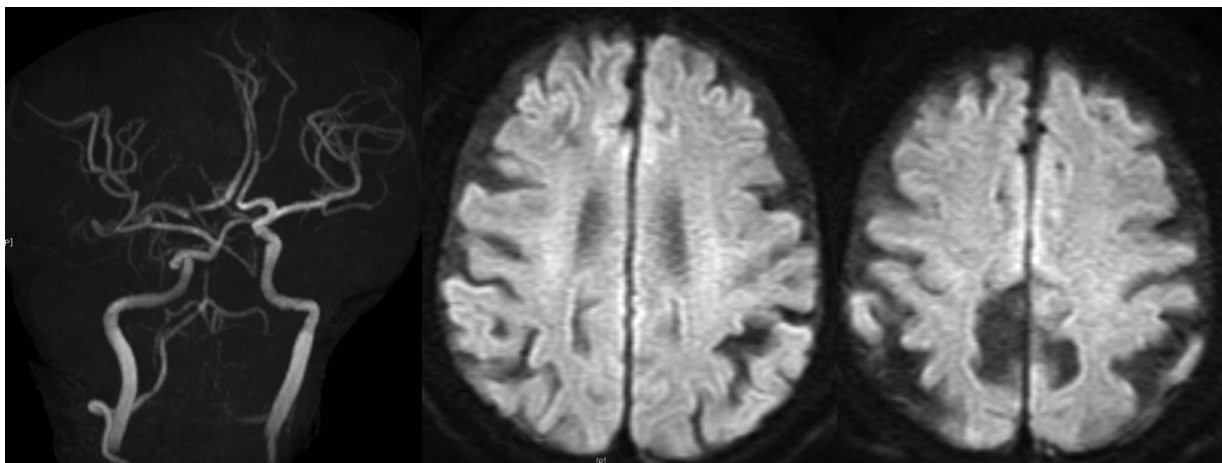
Magnetic resonance imaging and magnetic resonance angiography obtained 9 months after onset showing persistent primitive trigeminal artery (PPTA), internal carotid artery occlusion distal to PPTA, and no new infarctions.
